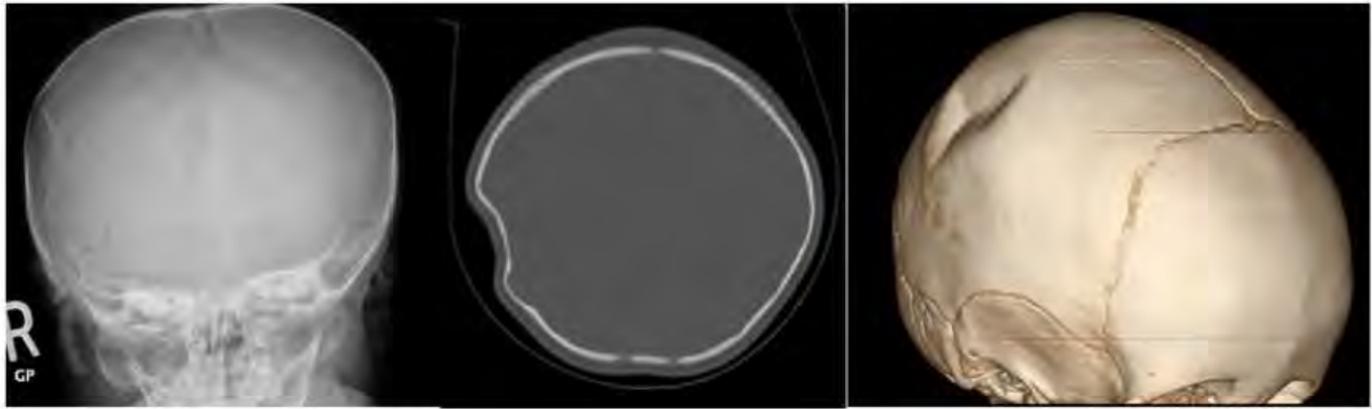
7-month-old boy who fell 3 feet from a changing table. Ap skull films, axial and 3D reformatted CT images demonstrate a concave depression of the calvarium without a discrete lucent fracture line. Note the absence of associated scalp swelling.
